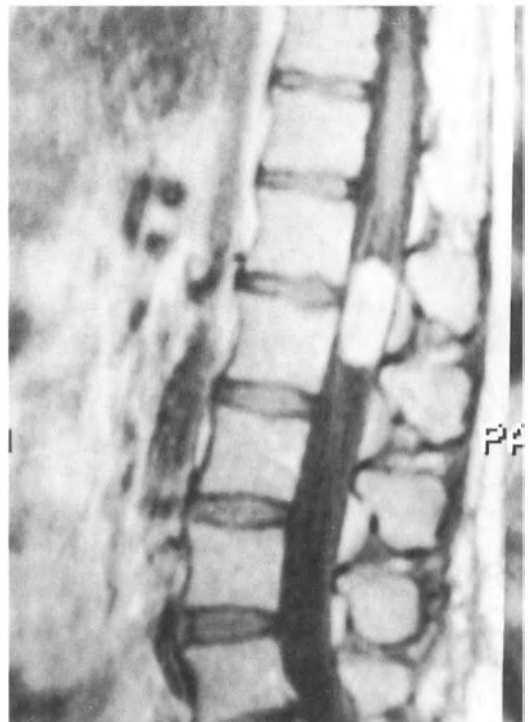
is a T1-weighted sagittal enhanced MRI image showing spinal cord widening with a hyperintense mass below the conus medullaris of a 21-year-old woman with low back pain and gait disturbance. Her symptoms had been considered somatoform prior to this MRI study. Surgery confirmed this to be an ependymoma.
